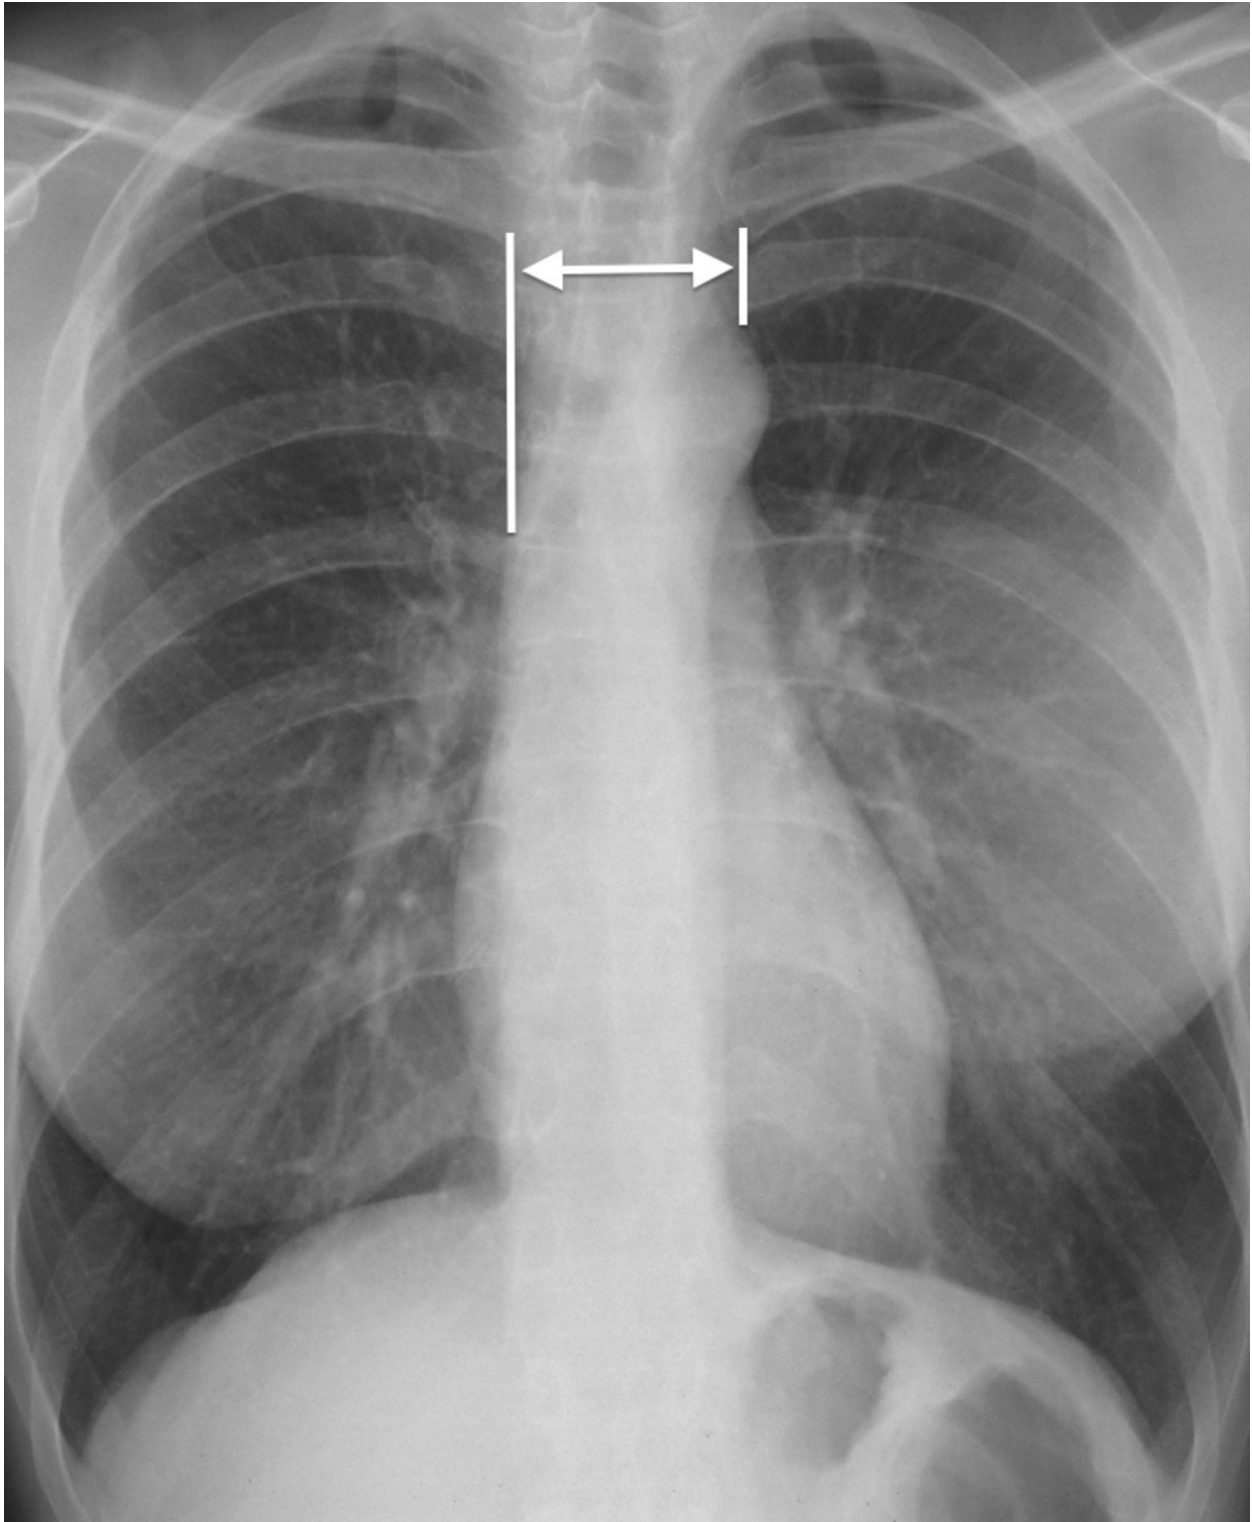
Chest radiograph of a patient with sarcoidosis. Right paratracheal (white arrow) and aortopulmonary (black arrow) lymphadenopathies.
